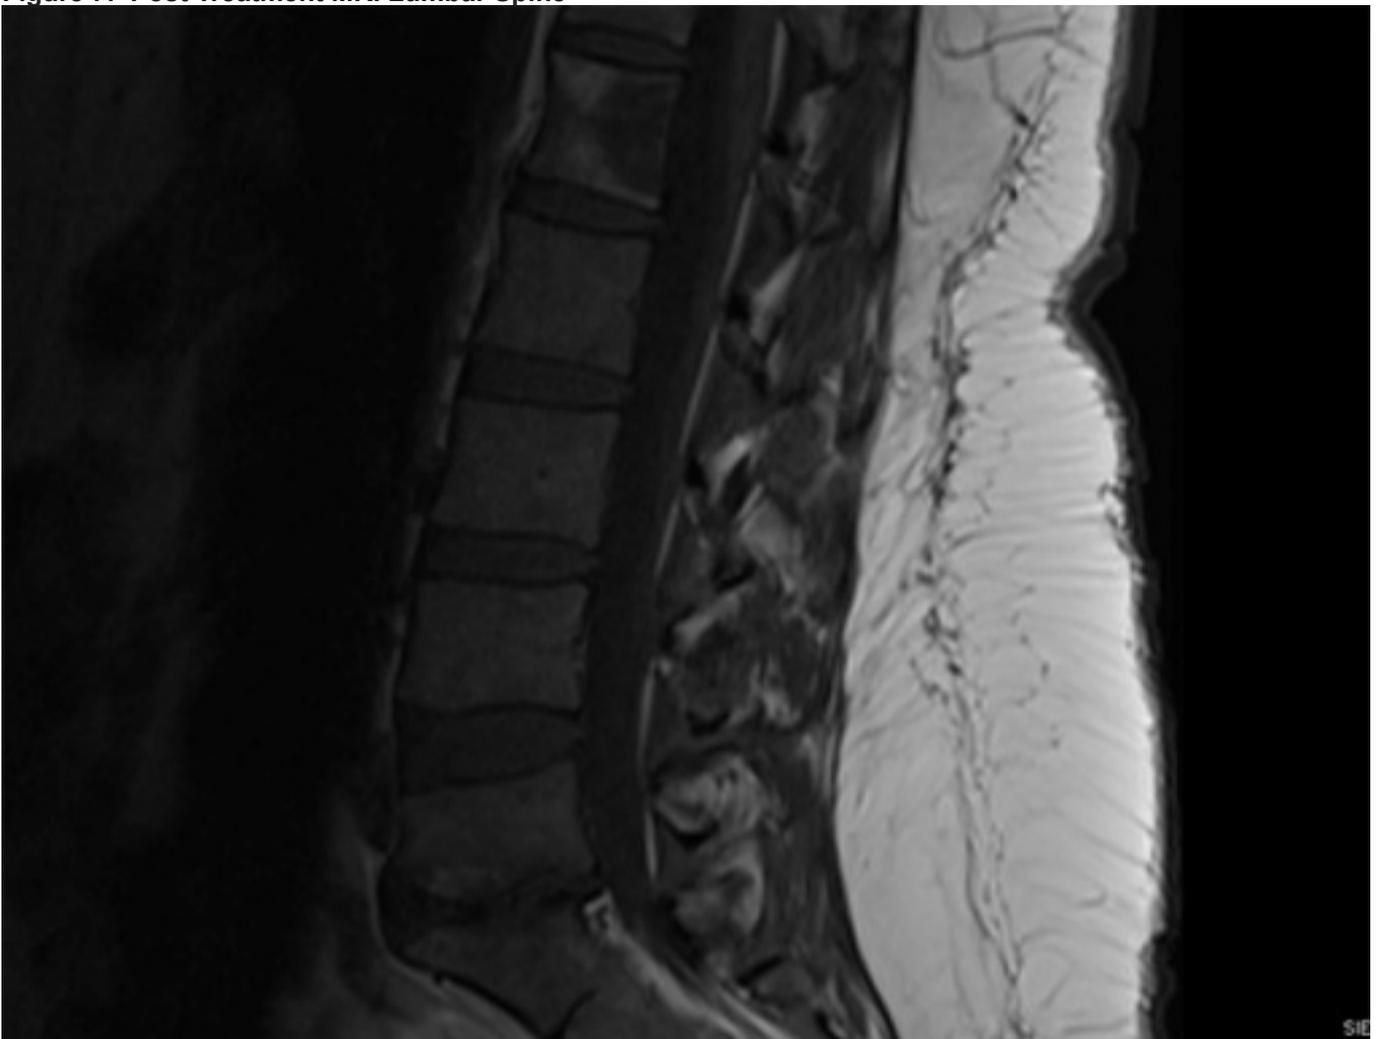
Post Treatment MRI Lumbar Spine
